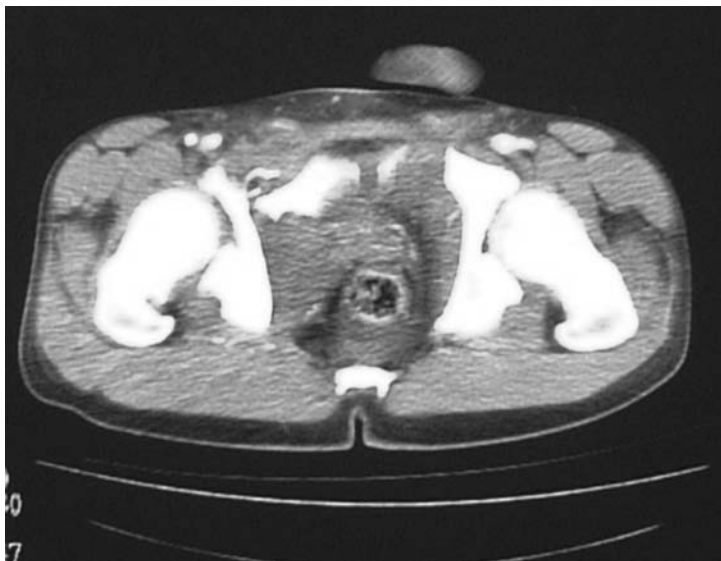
This is a computed tomography (CT) scan of the same case as in Figure 5.16 (open-book fracture). The degree of displacement of bone fragments looks much worse on CT.
